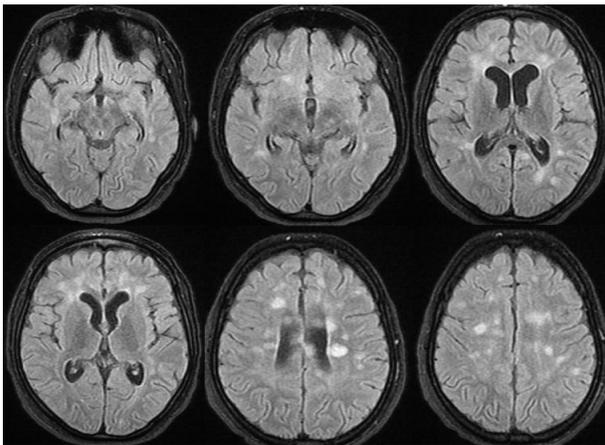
Brain MRI after 11 months from the first relapse.
